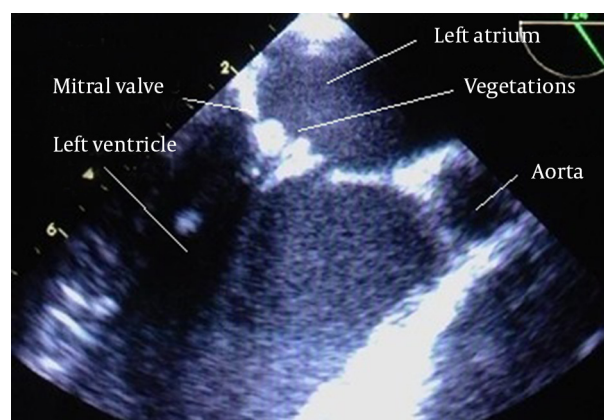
Long-Axis Transesophageal Echocardiography (TEE), Showing Multiple Irregular Masses on the Atrial Side of Both Mitral Leaflets
